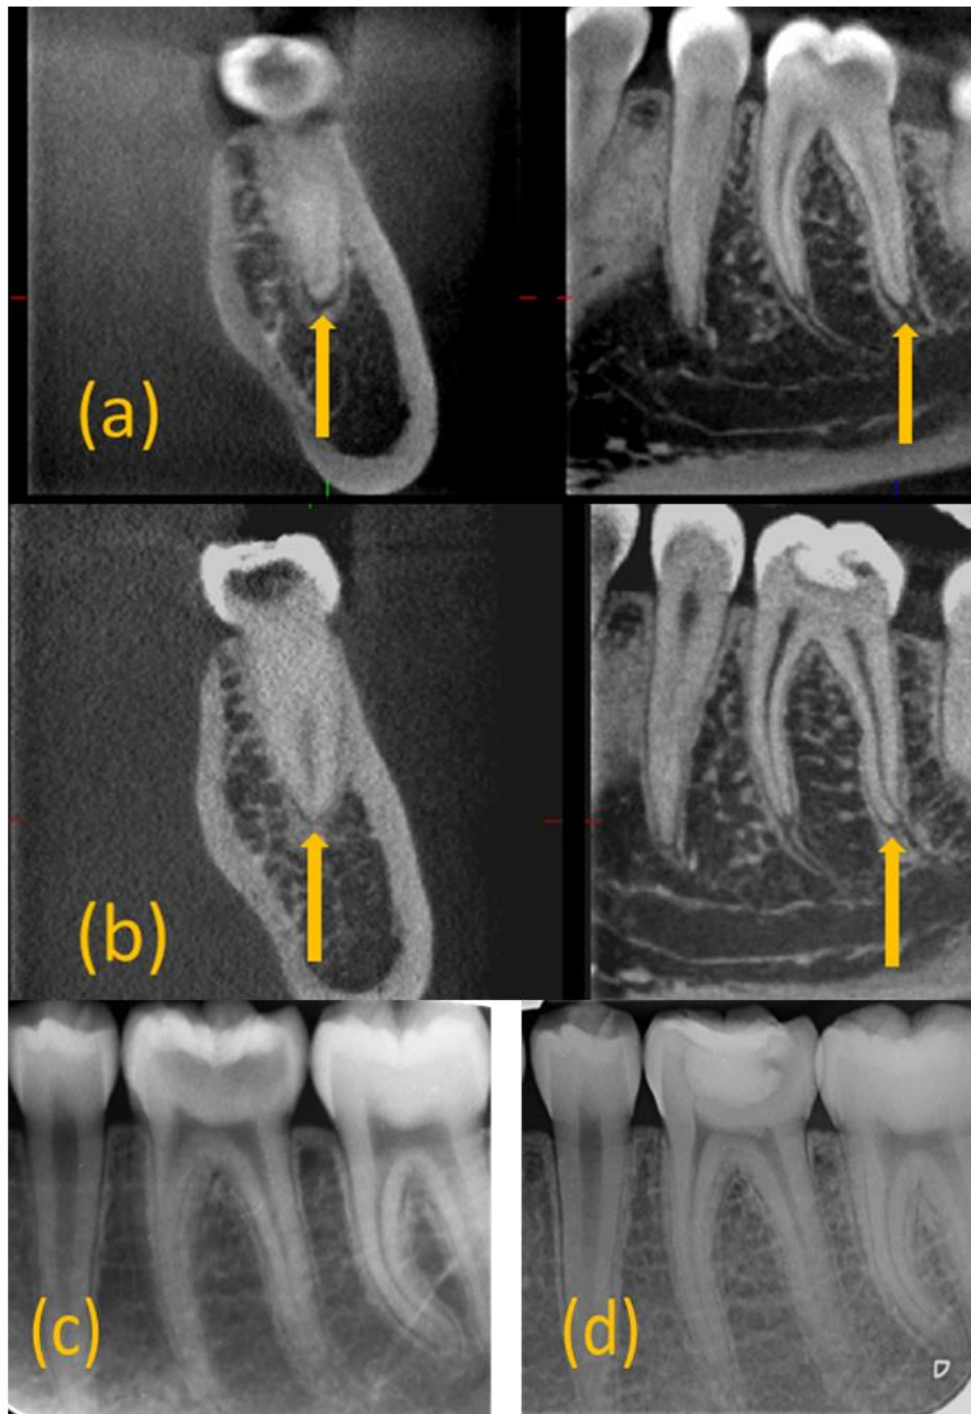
Example of healed lesion (a) CBCT at T0 revealing lesion in the distal root of the lower left 6. (b) CBCT at T12 revealing resolved lesion around the distal root of the same tooth.(c) PA radiograph at T0 revealing healthy periapical tissues around the lower left 6.(d) PA radiograph at T12 revealing healthy periapical tissues around the same tooth.
